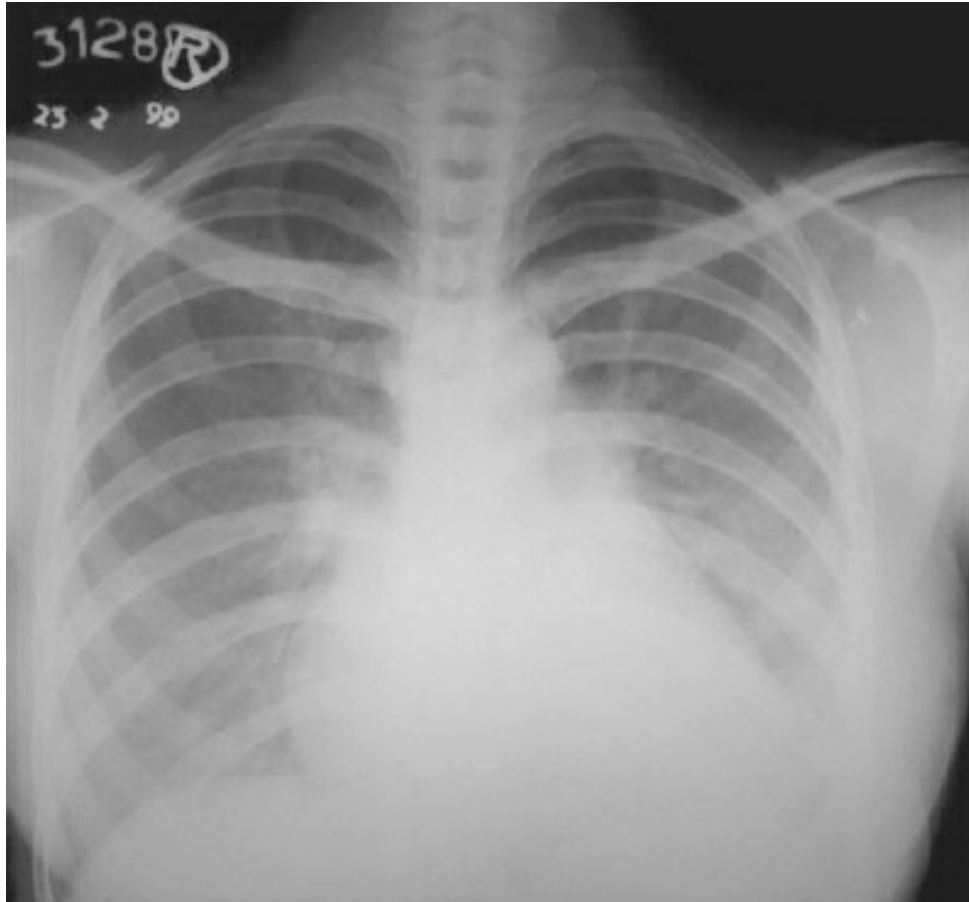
X-ray chest showing severe pulmonary artery hypertension in a patient with severe mitral regurgitation. Note the prominent main pulmonary artery and increased pulmonary vascularity.
